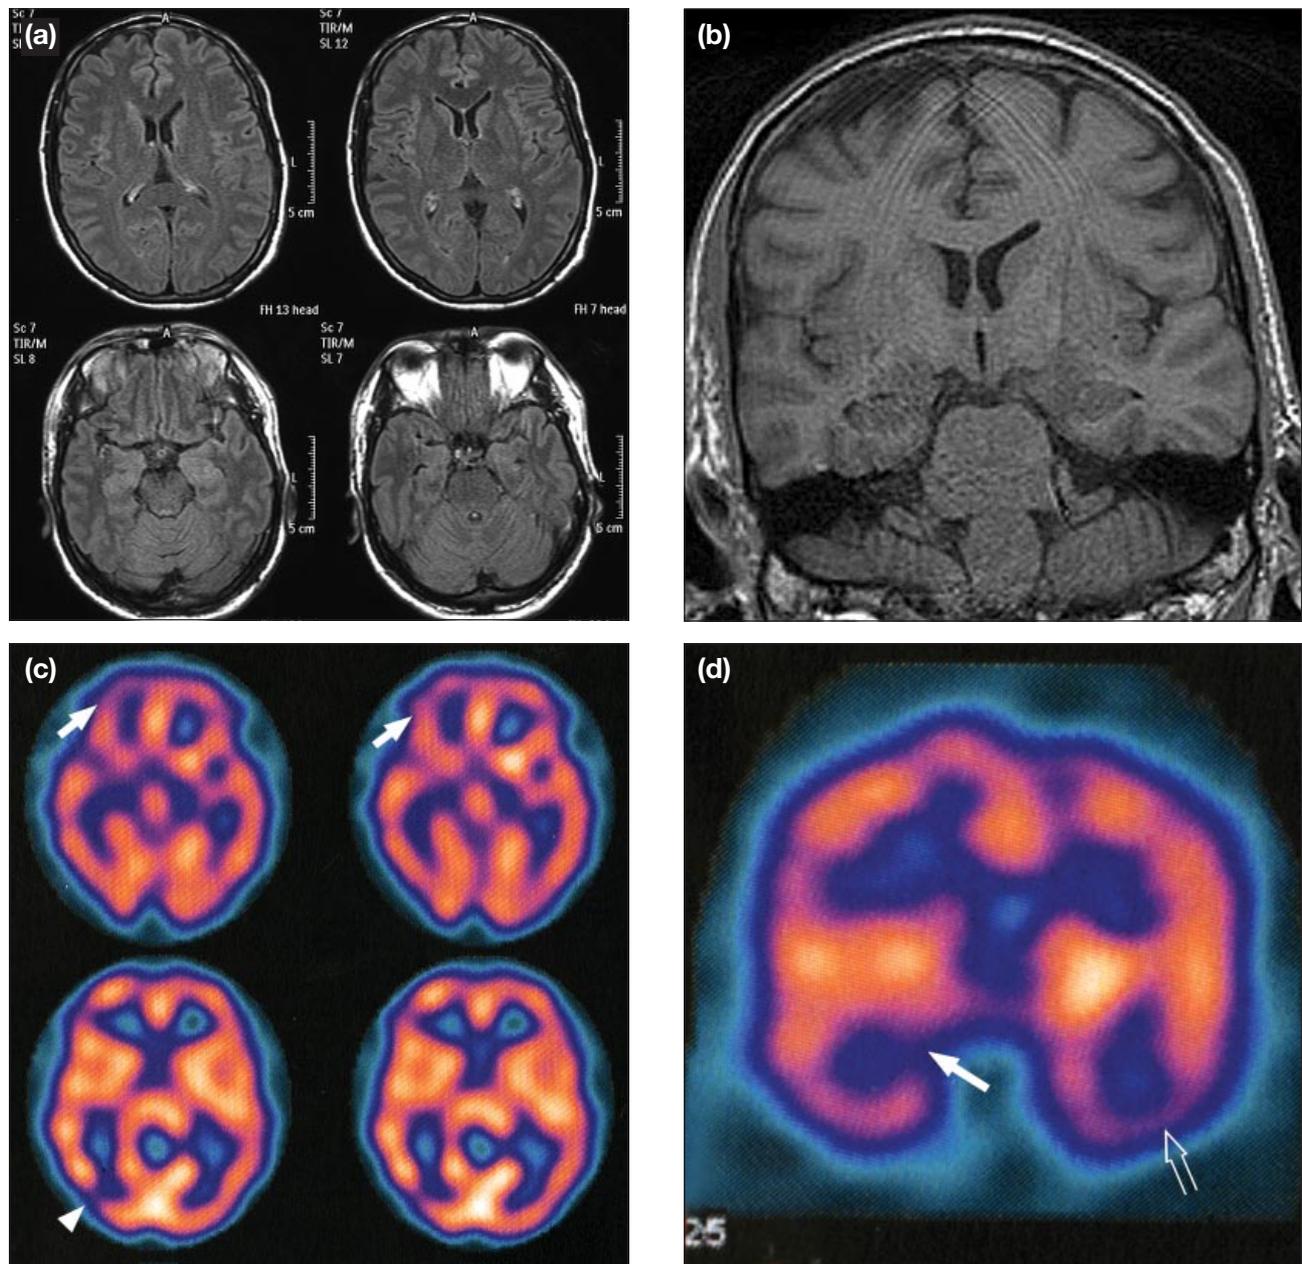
Imaging for patient 2. (a) Fluid attenuated inversion recovery axial magnetic resonance images were unremarkable with no evidence of infarction, white matter degenerative change, or cortical atrophy; (b) coronal T1-weighted magnetic resonance image of the brain was unremarkable; (c) axial single photon emission computed tomography showing right frontal lobe hypoperfusion (arrows) and right occipital lobe perfusion defect (arrowhead); and (d) coronal single photon emission computed tomography showing bilateral asymmetrical temporal lobe hypoperfusion.
